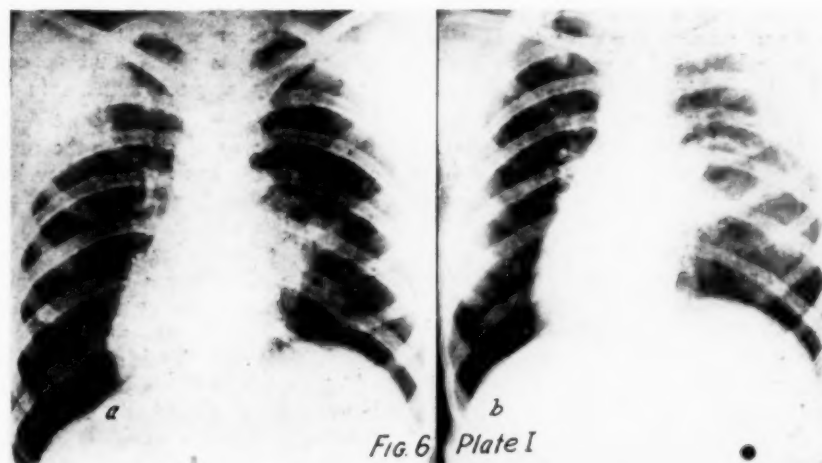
(a)—Plate I.—Acute inflammatory type of hilus pneumonia in an adult, with complications, showing a small rarefied area within the persistent hilus consolidation. About two weeks after crisis. (b)—Plate I.—Radiograph taken six days later. The rarefied area continues to enlarge
